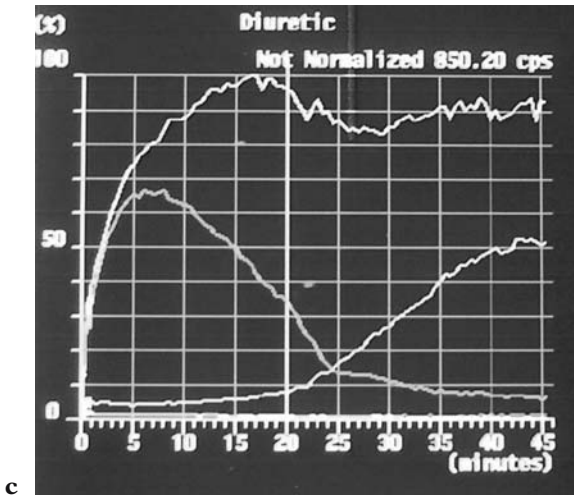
a: Right pelviureteric junction (PUJ) obstruction on ultrasound. b: PUJ obstruction on CT. Note the normal-calibre ureter with hydronephrosis above. c: MAG3 renogram of PUJ obstruction demonstrating obstruction to excretion of radioisotope by the kidney. (See this figure in full color in the insert.)
